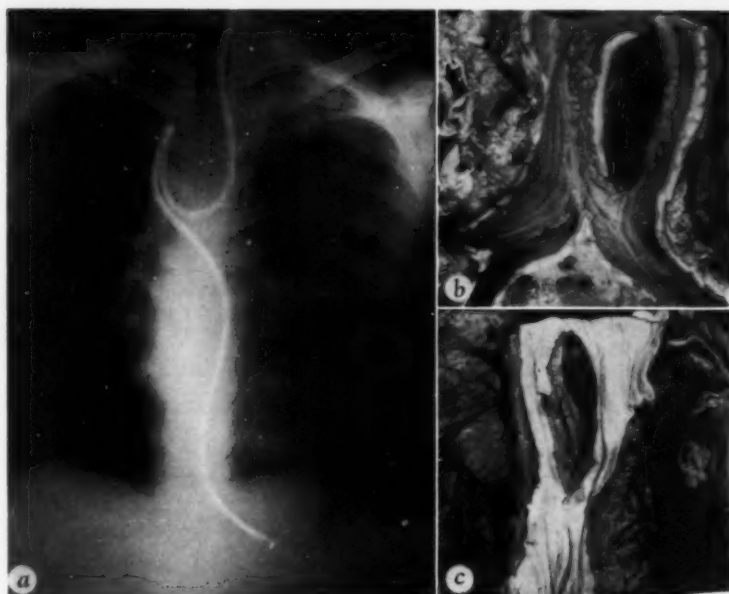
(case 1). *a.* Absence of roentgenographic signs of pneumothorax. Note coiled tube in esophagus and superior portion of stomach. *b.* Laceration through posterior wall of distal half of trachea. *c.* Laceration through anterior wall of middle third of esophagus.
